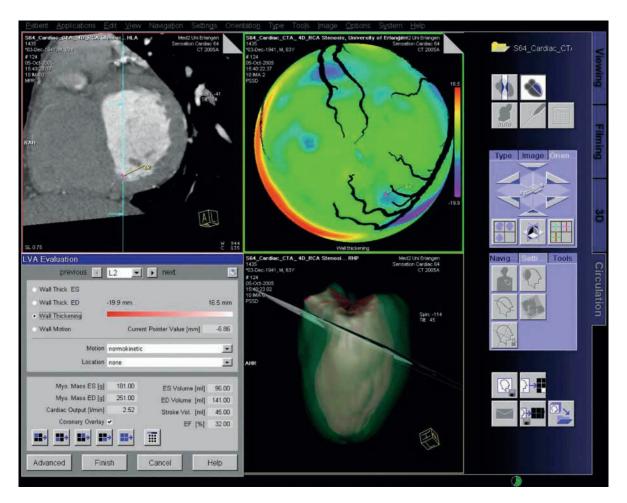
Retrospectively gated image acquisition by CT does not only contain information about the coronary arteries but also about the function of the myocardium. Newer post-processing is under development, and tries to determine the axial CT slices reconstructed at different time points of the cardiac cycle. These workstations may provide data about the global functional parameter, as well as regional wall motion abnormalities
